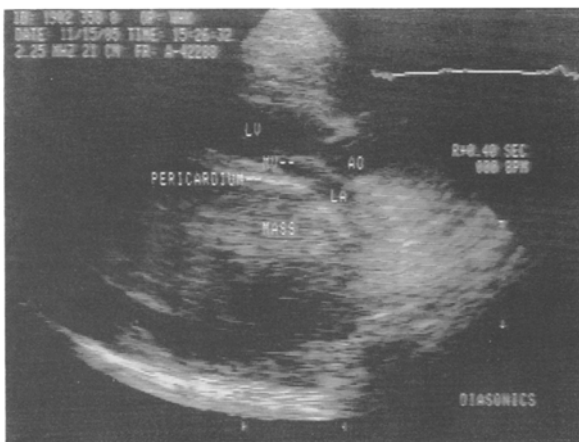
Parasternal long axis view showing a large clear space behind the left ventricle containing an echo dense mass possibly attached to the pericardium and bulging into pleural space consistent with a tumor.
